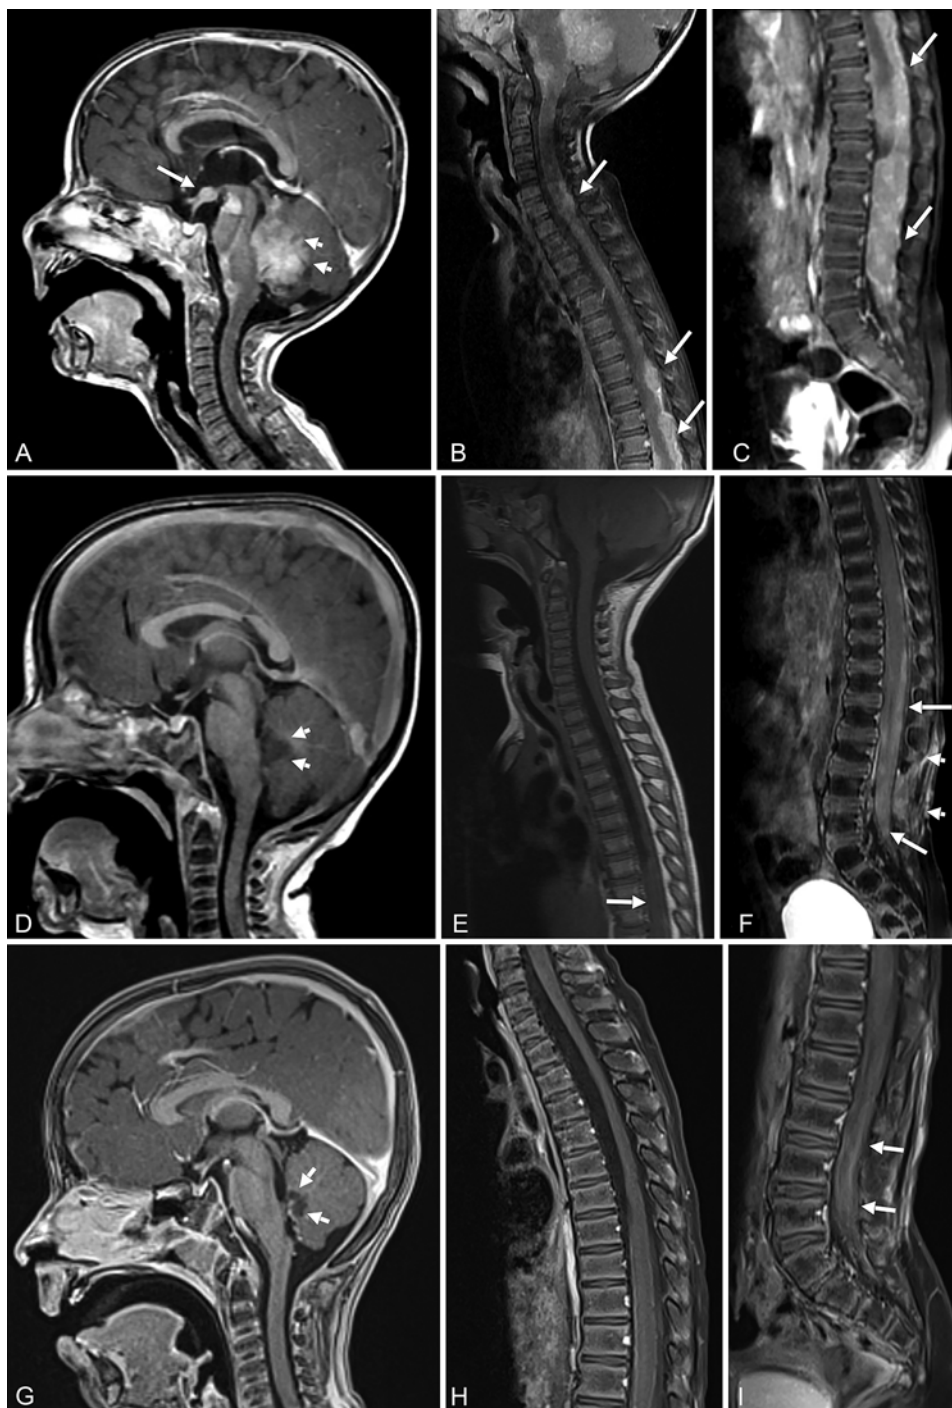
Patient 2. A–C: Midline sagittal postcontrast T1-weighted MR images of the brain (A) and spine (B and C) obtained at presentation in a 1-year-old patient with an M3 metastatic medulloblastoma showing a PF-enhancing tumor mass centered in the fourth ventricle (*short arrows*, A) and diffuse metastatic lesions, including a suprasellar metastasis (*long arrow*, A) and extensive thecal sac tumor masses (*arrows*, B and C). D–F: Midline sagittal postcontrast T1-weighted MR images of the brain (D) and spine (E and F) obtained at the end of treatment showing a small nonenhancing residual lesion in the PF (*arrows*, D) and complete resolution of intracranial metastasis. Postsurgical changes are seen at the laminectomy site, with enhancing scar tissue (*short arrows*, F). There is decreased size of extensive tumor metastasis in the thecal sac but without complete resolution (*long arrows*, E and F). Due to the extent of residual disease, a biopsy was performed, which was inconclusive. The patient continued maintenance therapy with oral temozolomide for an additional year. Due to stable imaging, no further treatment was pursued. G–I: Midline sagittal postcontrast T1-weighted MR images of the brain (G) and spine (H and I) obtained at the 5-year follow-up showing a small nonenhancing residual change at the PF tumor bed (*arrows*, G) and a continuous decrease in size of persistent mildly enhancing changes within the lumbar thecal sac (*arrows*, H and I). This patient remains a long-term survivor and was 13 years of age at the time of the study.
